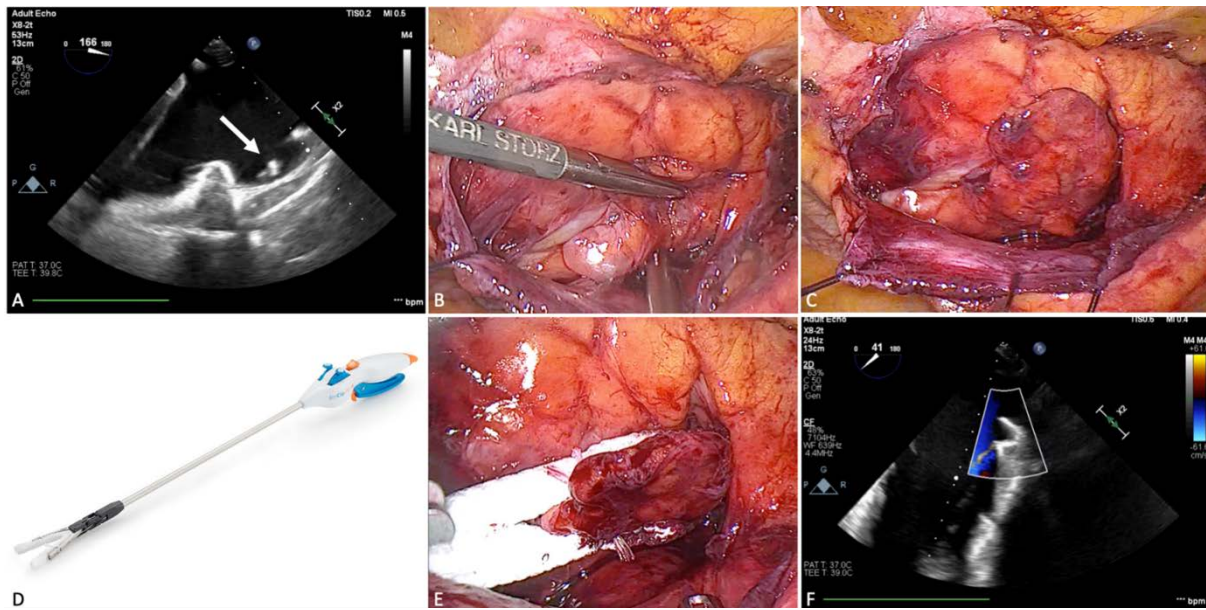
Intra-operative transesophageal echocardiography (A) white arrow points to the dense thrombus in the left atrial appendage (LAA); thoracoscopic adhesions removal and LAA visualization; pericardial traction sutures in place (B). LAA fully mobilized (C). AtriClip® PRO-V thoracoscopic device (D). PRO-V clip placement (E). Echo shows acceptable closure of the LAA (F)
